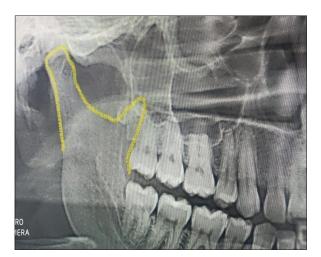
Orthopantomogram showing triangular coronoid process
